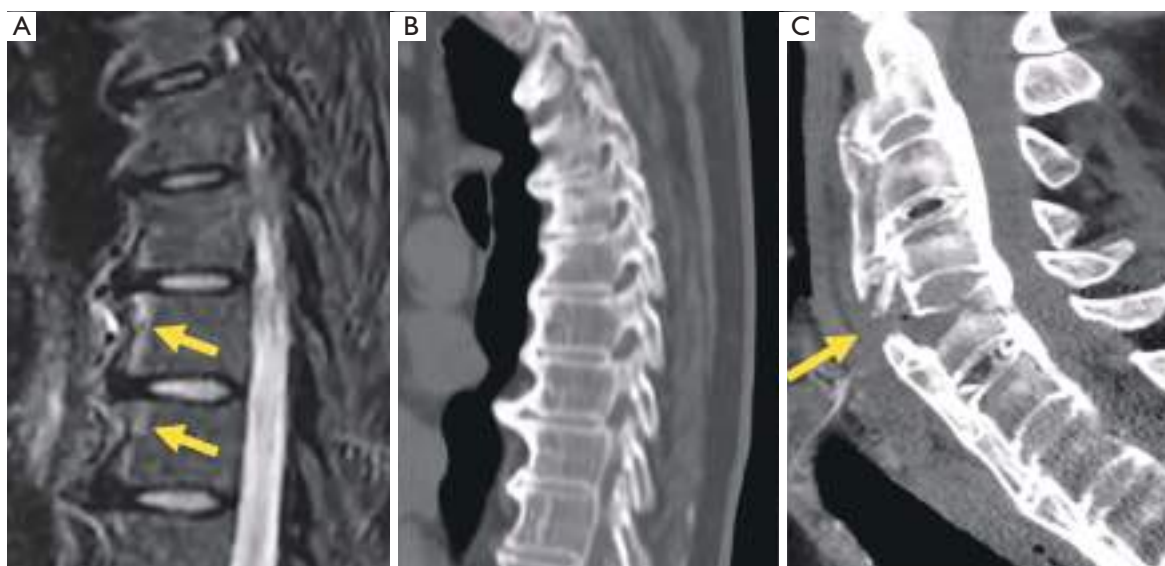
DISH. (A) Sagittal STIR showing subligamentous edema (arrows). (B) Sagittal reformatted CT showing bridging osteophytes. (C) Sagittal CT of low energy cervical fracture in a patient with DISH (arrow). DISH, diffuse idiopathic skeletal hyperostosis; STIR, short tau inversion recovery; CT, computed tomography.
